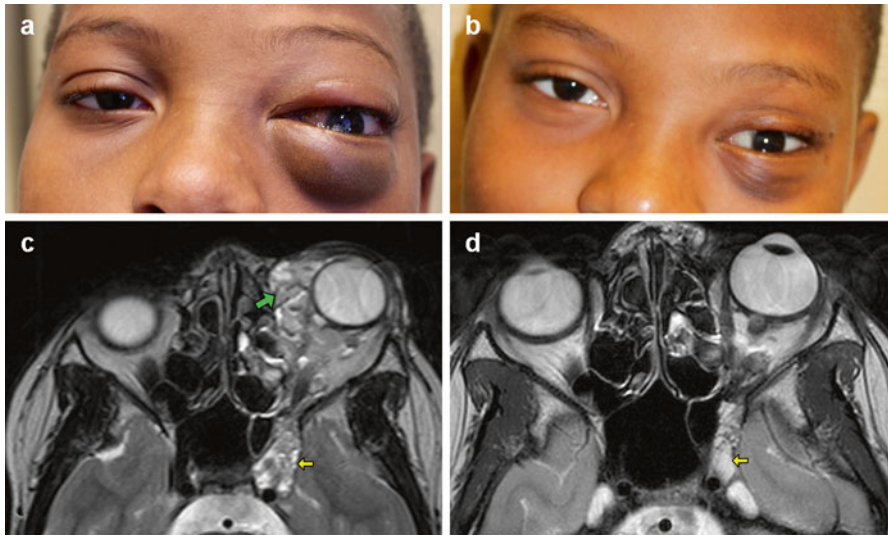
A 3-year-old girl with microcystic lymphatic malformation of the left orbit: comparison of pre- and post-sclerotherapy images. (a, b) Clinical photographs showing resolution of proptosis and ecchymosis. (c, d) Axial T2W MRI showing complete resolution of malformation after one sclerotherapy session
